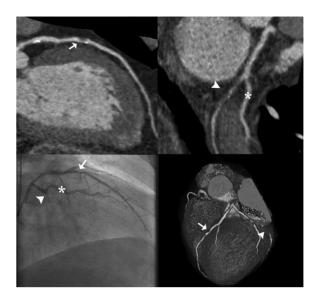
A 59 year-old male presented with acute chest pain. Coronary CTA was performed in the emergency department, which showed obstructive disease of the left anterior descending artery (arrow) and an occlusion of the left circumflex artery (arrowhead). On the catheter angiogram, the lesions in the left anterior descending and left circumflex artery is portrayed. The occlusion of the left circumflex is denoted by the abrupt filling of the contrast after the bifurcation of the first marginal branch (asterisk).
